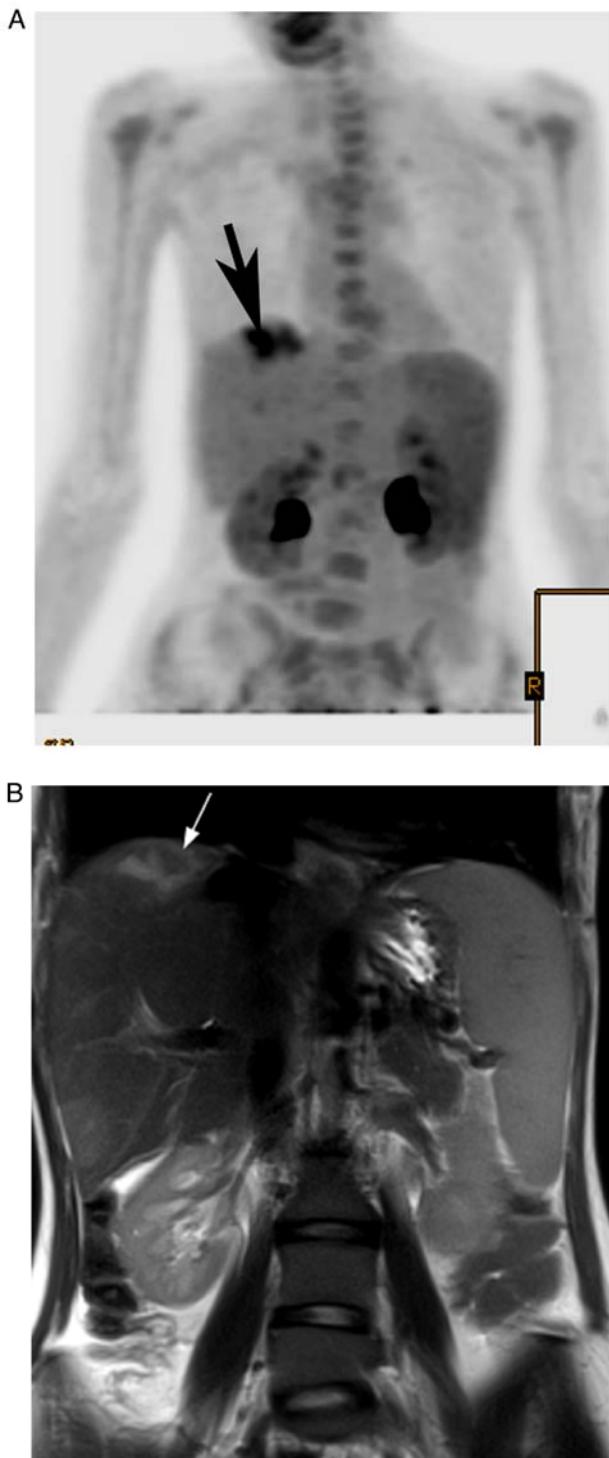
FDG positron emission tomography/computed tomography scan of a patient with fever of unknown origin diagnosed with liver phlegmon/abscess. (A) Coronal maximum intensity projection demonstrated abnormal focal uptake in the dome of the liver (arrow). (B) Coronal half-Fourier acquisition single-shot turbo spin-echo demonstrated a high signal area in the liver dome, corresponding to abnormal FDG uptake (arrow). (C) Coronal post-contrast T1-weighted image revealing a heterogeneous area of low signal intensity in the same area in the liver dome (arrow). The patchy geographic areas of hepatic parenchyma signal alteration, and rim enhancing branching tubular structures were highly suggestive of an inflammatory/infectious process with phlegmonous changes but with no drainable hepatic abscesses. FDG, fluorodeoxyglucose.
